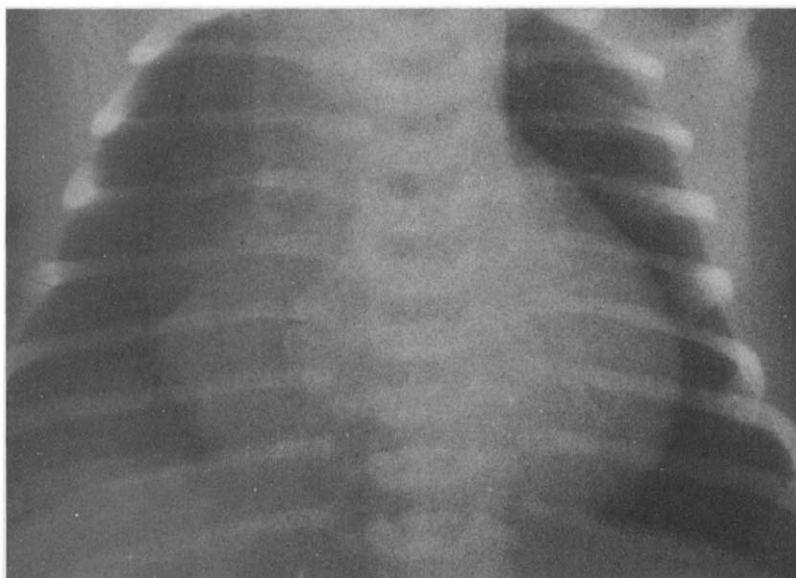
Chest X-ray film on hospital admission. The infant is slightly rotated. The cardiac silhouette is enlarged with a cardiothoracic ratio of 0.64. An opacity is evident in the right lower lobe of the lung.
